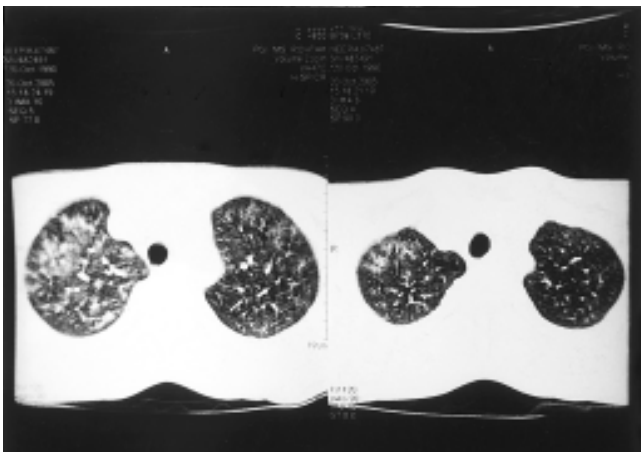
CT scan chest showing upper section
